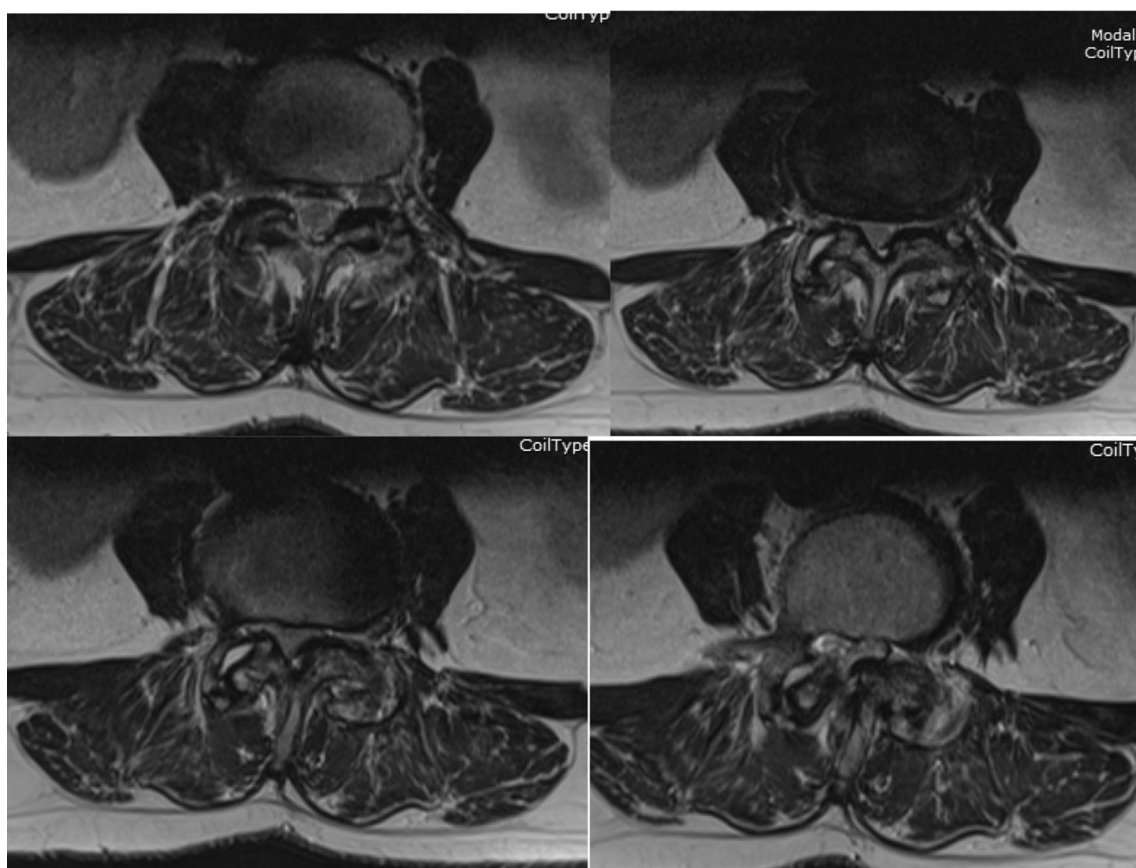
Axial T2-weighted MRI sequences through L3/4 disc space (cranial to caudal)
